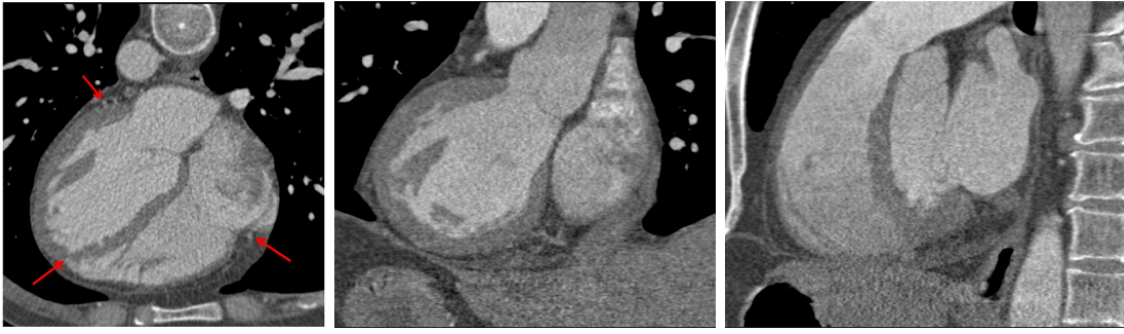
CTA images in transversal, coronal and sagittal views. Red arrows point to the right coronary artery; yellow arrow shows the left coronary. From [Zhang, 2010].
